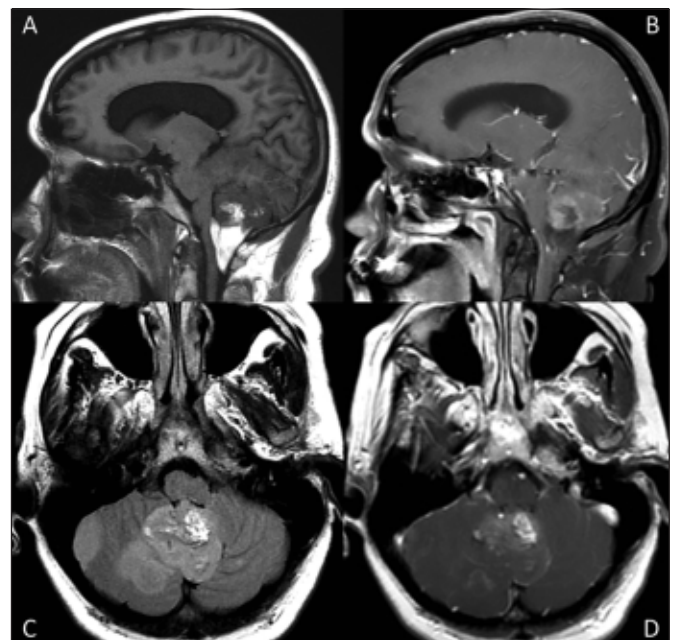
(A) Sagittal T1-weighted MR image of the brain demonstrates a midline mass with fatty (hyperintense) and solid (hypointense) components. (B) Sagittal T1-weighted MR image with gadolinium contrast and fat saturation. The fatty portions of the mass are now hypointense. The solid portions demonstrate enhancement. (C) Axial FLAIR MR image demonstrates the hyperintense midline mass as well as a second separate FLAIR hyperintense right lateral cerebellar mass. (D) Axial T1-weighted image with gadolinium demonstrates enhancement of the solid portions of the midline mass as well as faint enhancement of the second separate right lateral cerebellar mass.
